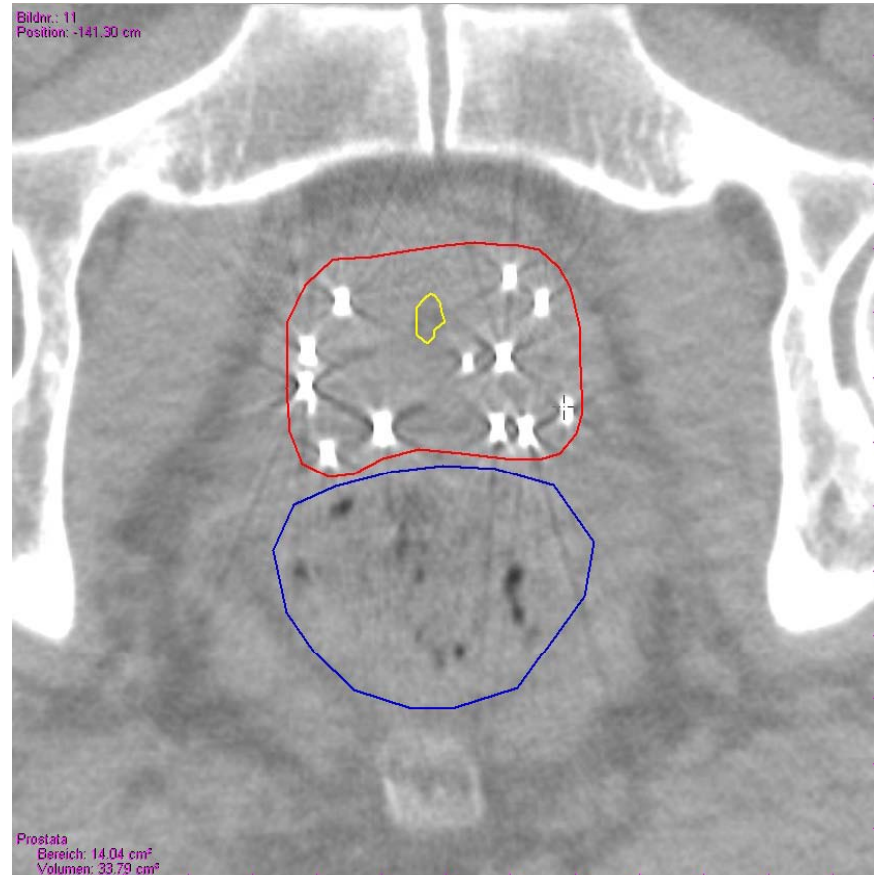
The seed-images (white dots) on a transverse CT scan.
